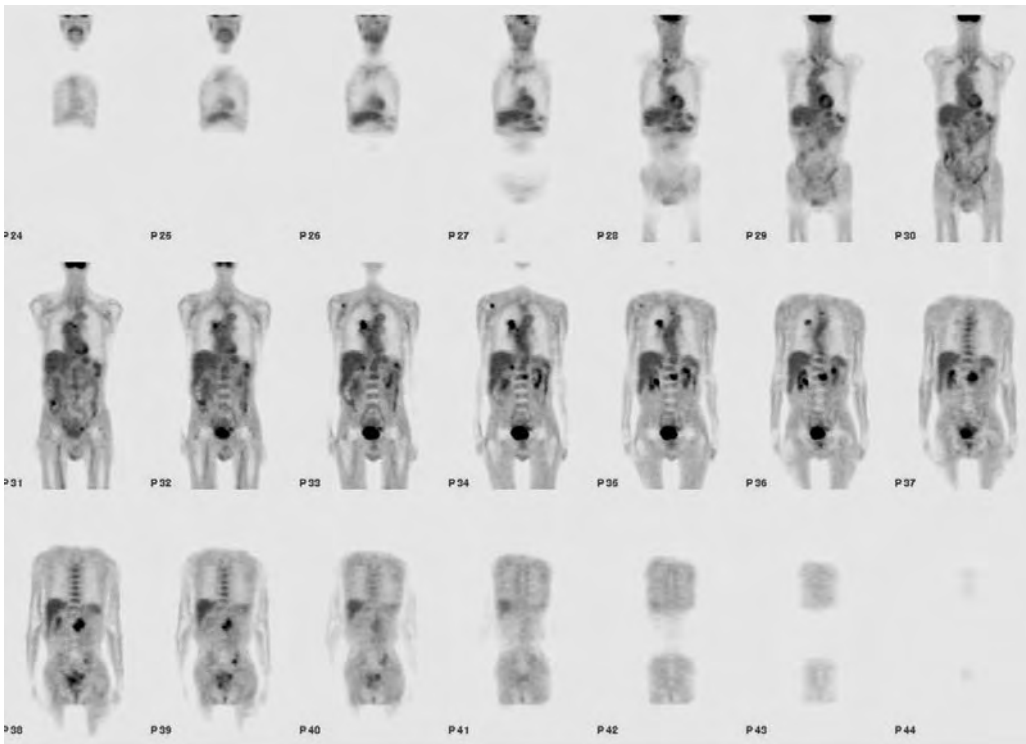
Coronal PET images of a 70-year-old man with newly diagnosed non-small cell lung cancer of the right lung. The CT showed the primary tumor in the right upper lobe, near the superior aspect of the hilum, with borderline mediastinal lymphadenopathy, and negative adrenal glands. PET images are corrected for attenuation, and show intense hypermetabolism in the primary tumor (P32–P36), with a lesion medially of this tumor (P34), consistent with a malignant lymph node. An additional soft tissue lesion is seen in the right adrenal gland (P33–P44) and right lower neck (P28). Foci are seen in the right scapula (P33–P34), L2 (P34–P37) and L3 vertebral bodies (P37–P38), and in the left sacrum (P38–P39) consistent with bone metastasis. Imaging was performed 1 h after 15.2 mCi FDG, on an ECAT EXACT system (CTI, Knoxville, TN). Coronal slice thickness was 10 mm
